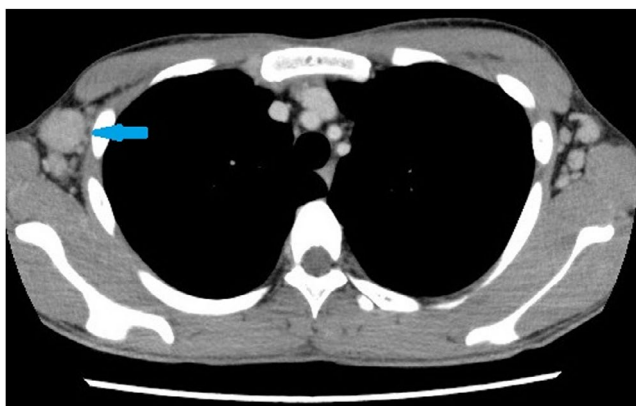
Transverse section of contrast-enhanced CT scan. Axillary lymphadenopathy: arrow (2.5 × 1.9 cm)
